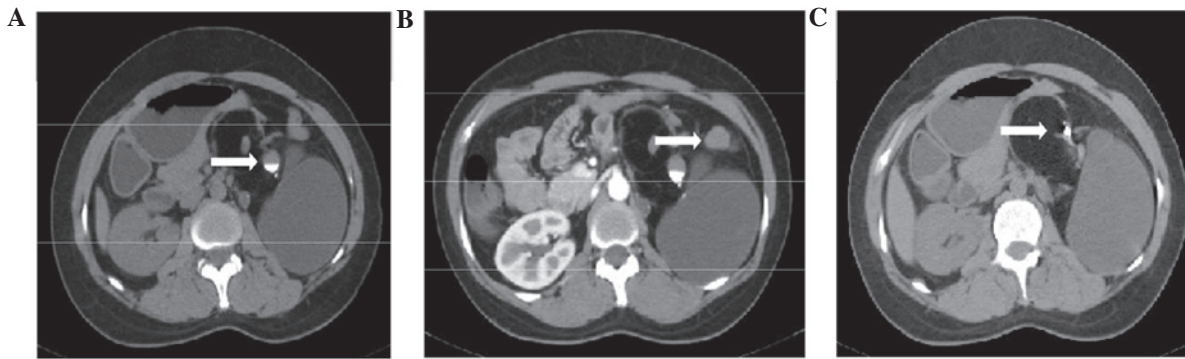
(A) Computed tomography (CT) scan indicating an irregularly-shaped mass in the left retroperitoneal region. Note the dependent high attenuating material (arrow) consistent with calcium. (B) Contrast-enhanced CT demonstrated no enhancement of the mass, however, the soft tissues in the lesion showed slight enhancement (arrow). (C) Calcification (arrow) in the soft tissues of the lesion.
